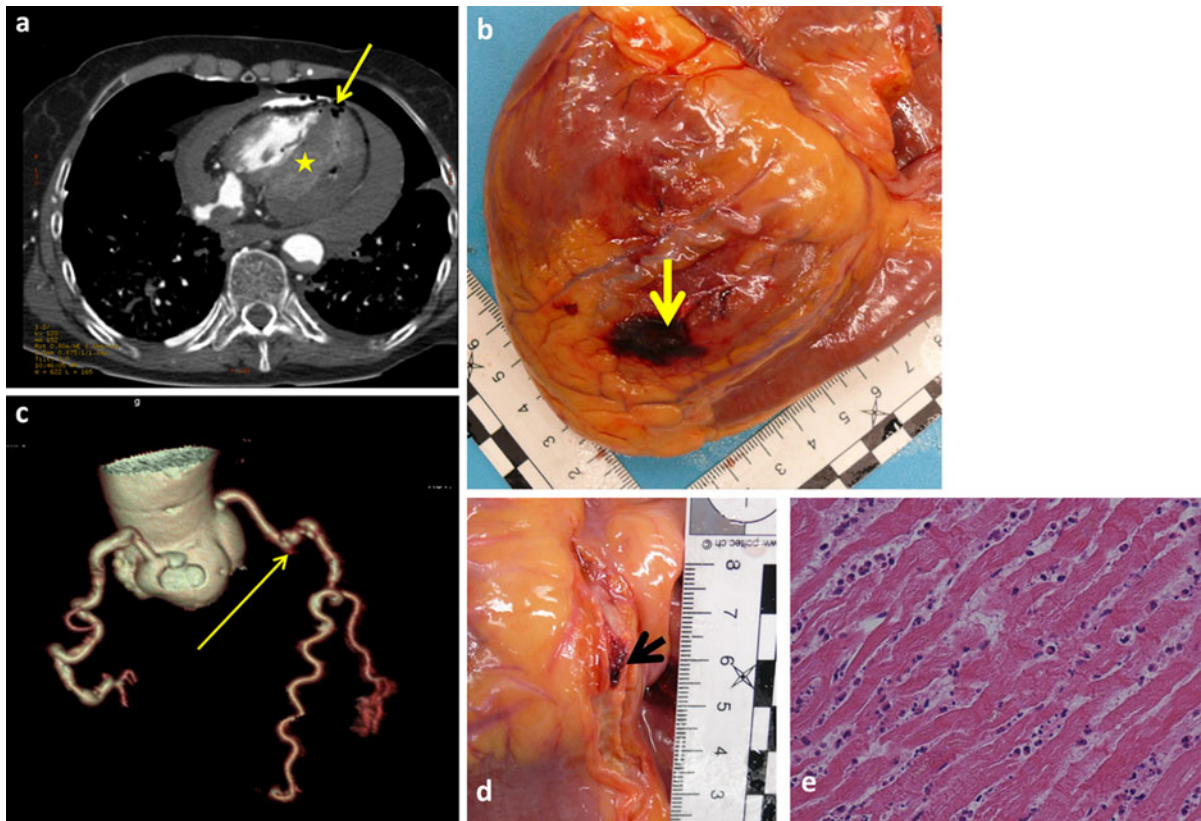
Subacute infarct related to LCX thrombosis and hemopericardium in a 67 year old woman (case no 13). Rupture of the posterior wall (*arrows*) in CT angiography (a) and at autopsy (b). An enhancement of the infarcted myocardium is observed (*asterisk* in a) during the arterial phase of PMPCTA. 3D-reconstruction (c) performed on data of the arterial phase
